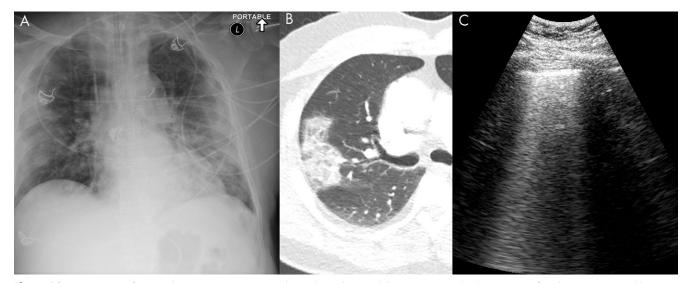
COVID-19 infection on lung US. A, Anteroposterior chest radiograph, B, axial chest CT image, and C, lung US image from the same 74-year-old man, who tested positive for COVID-19 5 days prior to imaging. The chest radiograph shows bilateral peripheral opacity, which presents with a ground-glass appearance on the chest CT image. Lung US imaging in this patient demonstrated numerous B-lines throughout the parenchyma which were diffusely confluent in some sections. These are better seen in a cine clip (Movie 9). A small consolidation in a patient with COVID-19 is shown in Movie 10.
